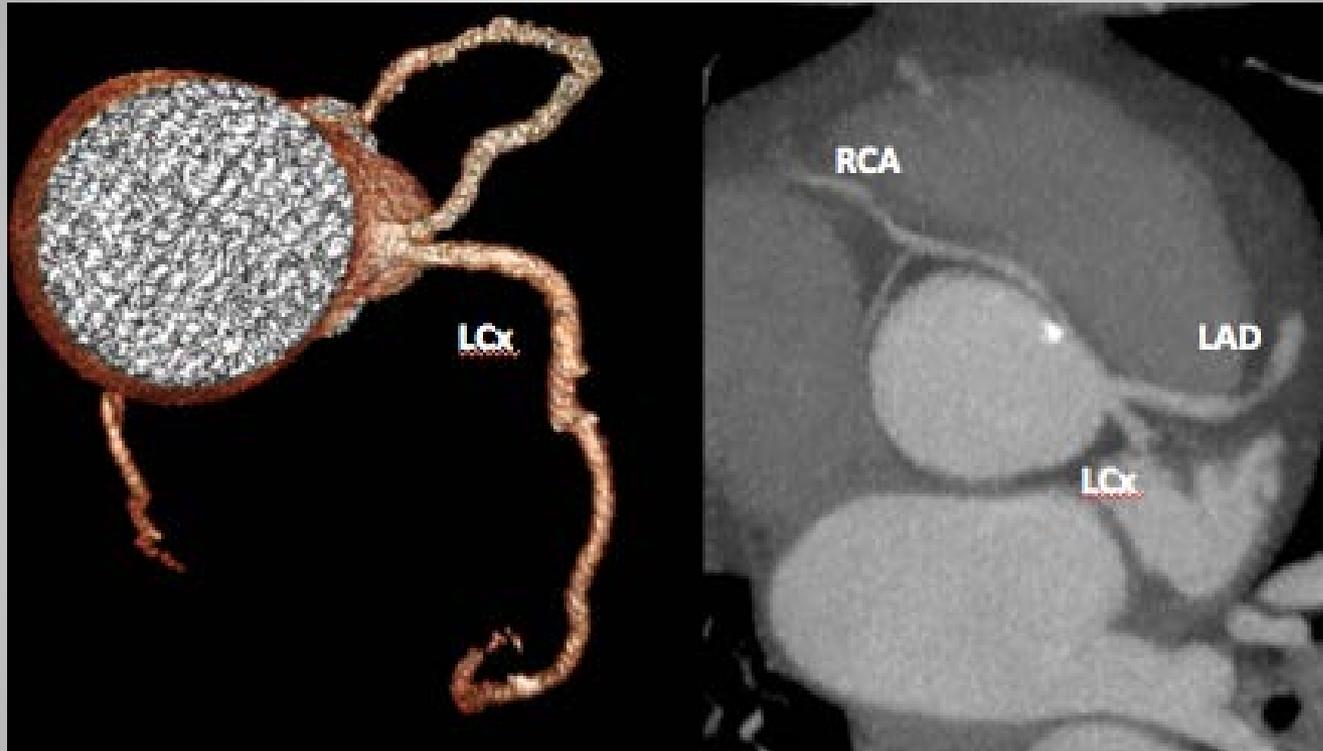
Image from CT coronary angiography in 25 year old male (screening study) demonstrating right coronary artery arising from the left coronary sinus and coursing interarterially.
